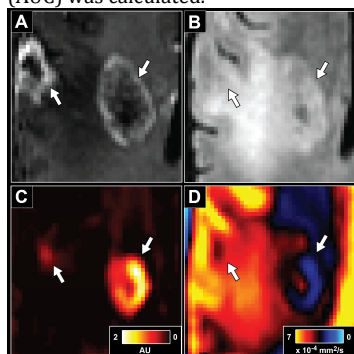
Comparison of RSI-CI vs. ADC in the same patient as Fig 1. (A) T1-post Gd (B) T2-FLAIR (C) RSI-CI (D) ADC. Arrows indicate areas of biopsy confirmed tumor. Note the high sensitivity of ADC to edema (FLAIR hyperintensity). Also note the lateral (left) tumor site that is easily identified by RSI-CI but not ADC.
